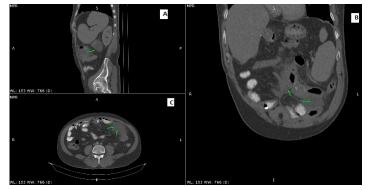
Computed topography (CT) scan of the abdomen showing intraperitoneal collections (green arrows) obtained in different planes A. sagittal, B. coronal and C. axial.
